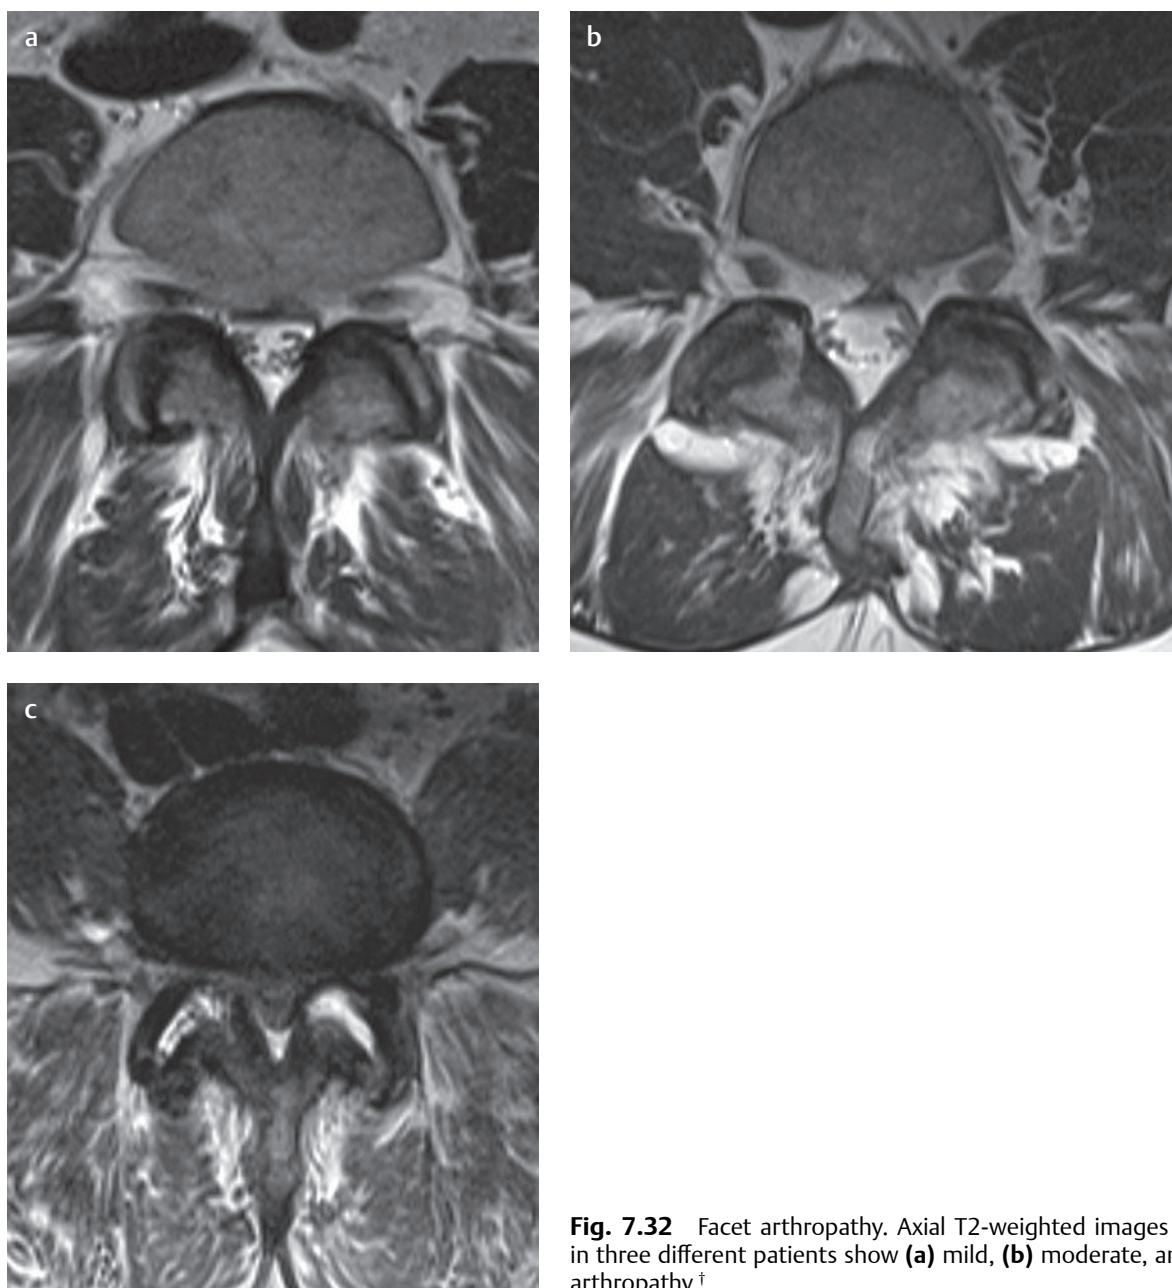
Facet arthropathy. Axial T2-weighted images at the L4-L5 level in three different patients show (a) mild, (b) moderate, and (c) severe facet arthropathy.[†]
